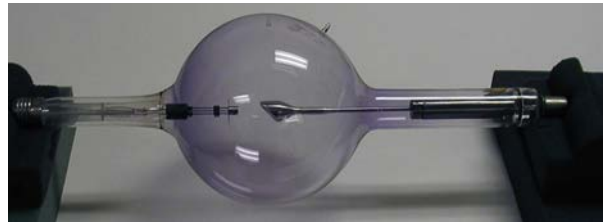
The Coolidge “hot cathode” x-ray tube, prototype of modern tubes, was introduced in 1910.
